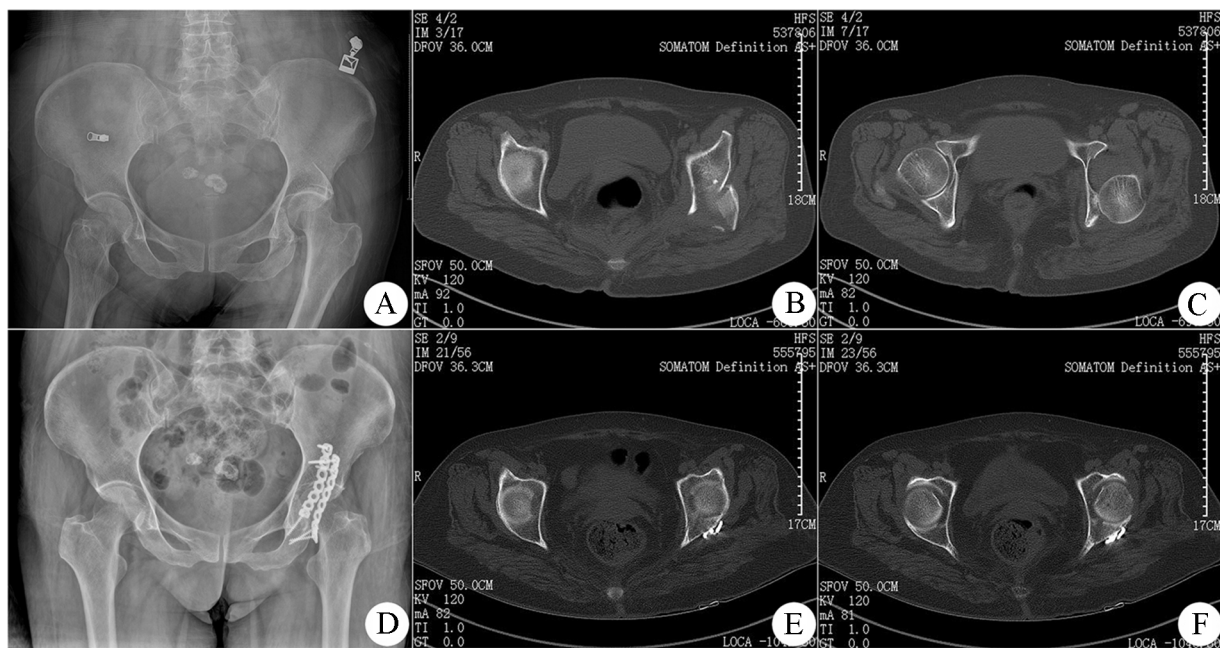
Preoperative and postoperative radiograph and CT scan: (a) preoperative radiograph of anteroposterior view; (b) preoperative CT scan showed posterior wall fracture of the acetabulum and fragment displacement; (c) preoperative CT scan showed acetabulum fracture combined with posterior dislocation of femoral head; (d) postoperative radiograph; (e) postoperative CT scan showed the fracture end had good para-position and alignment; (f) CT scan showed dislocated femoral head was in position after operation.
